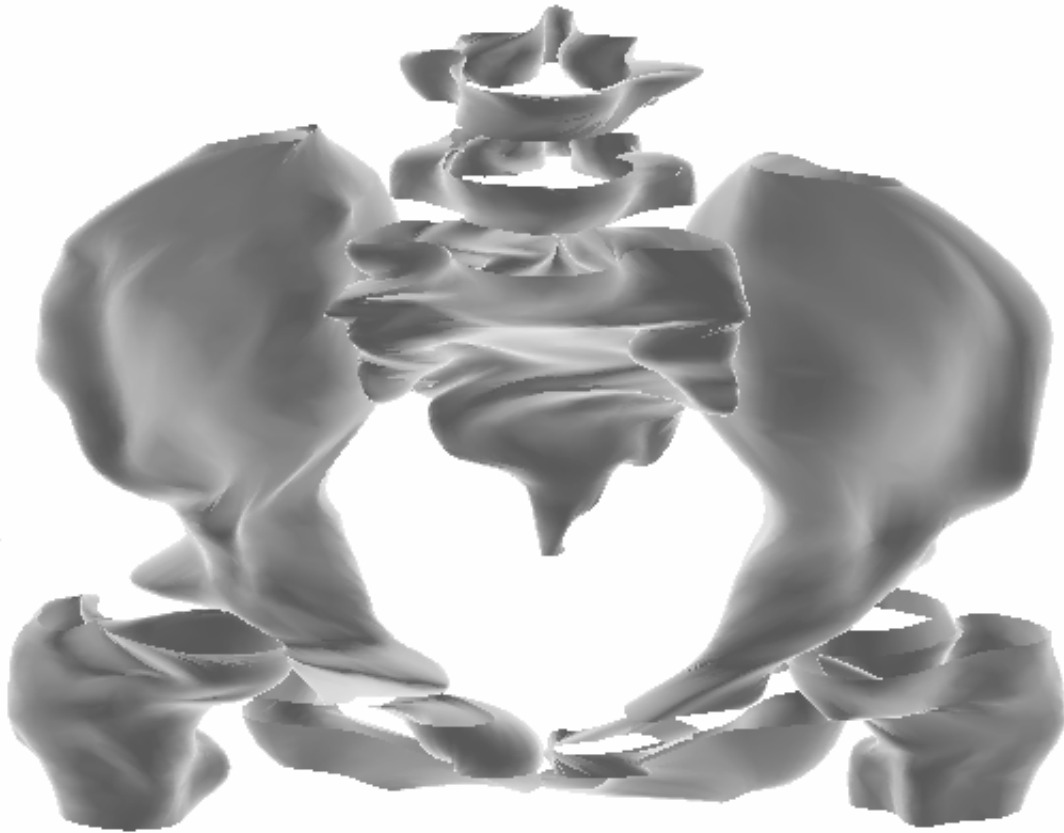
The major tube-like structures of the bones in the CT scan are rendered.
